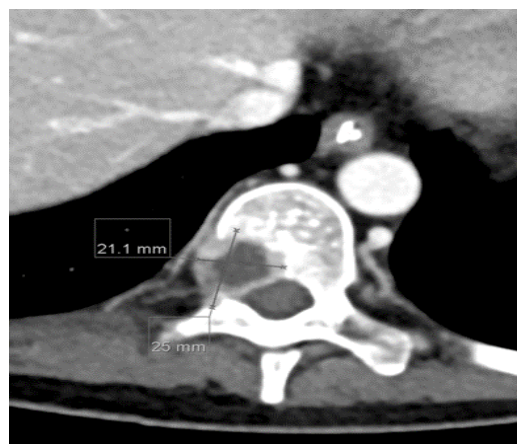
axial CT scan showing D10 hemispherical lytic lesion.
